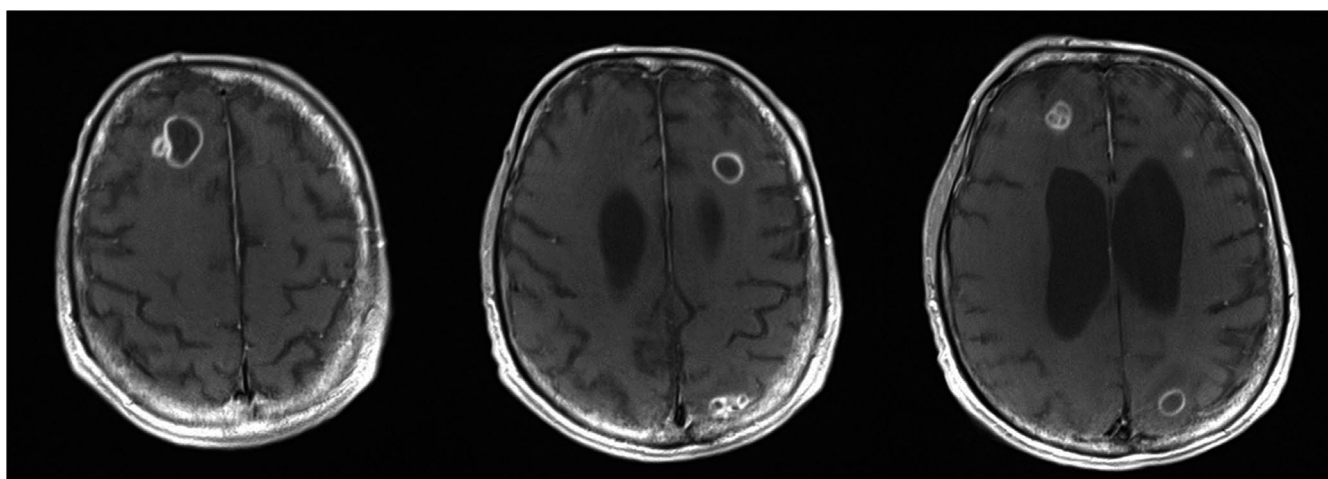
Contrast enhanced T1-weighted MRI showing multiple brain abscesses of different size
